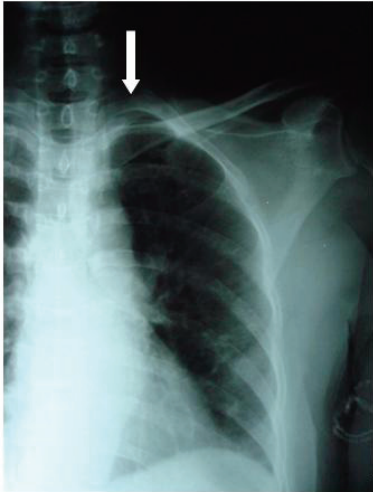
chest X-ray of the patient (PA view) showing osteolytic destruction of the sternal end of left clavicle (arrow)
